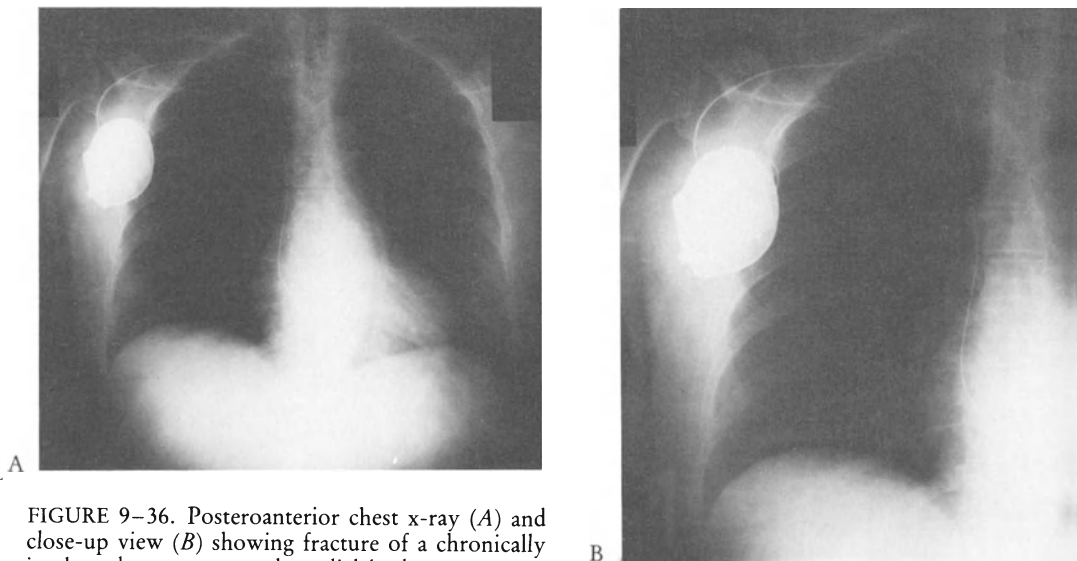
Posteroanterior chest x-ray (*A*) and close-up view (*B*) showing fracture of a chronically implanted permanent endocardial lead.
